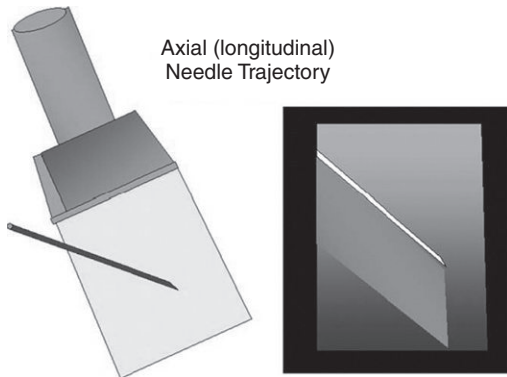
Hyperechoic image of an in-plane (axial/longitudinal) needle insertion. From Grau T. *Ultrasonography in the current practice of regional anesthesia. Best Practice and Research Clinical Anaesthesiology.* 2005;19:175-200.
